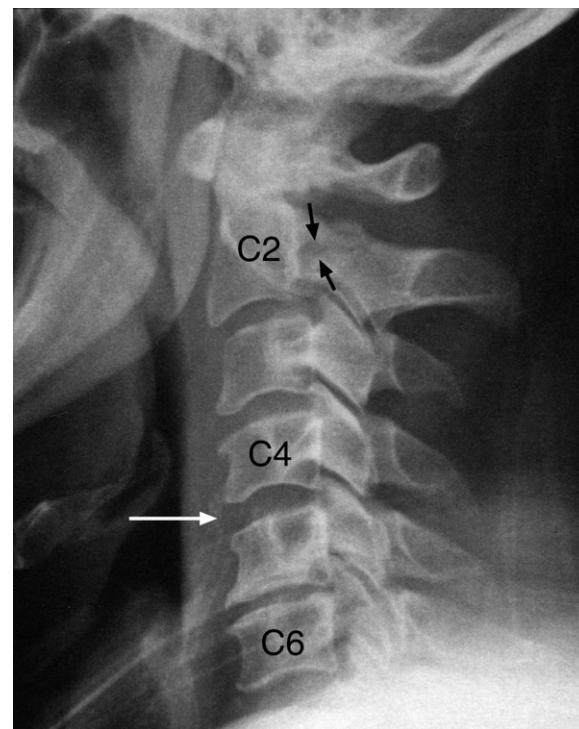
Cervical spine lateral plain X-ray image. Note (i) the anterior slip of C2 on C3 in view of the hangman's fracture at C2 (arrows) (due to associated ligamentous and disc injuries at this level), (ii) the possible compression of the antero-superior aspect of the C4 body, (iii) the widening of the C4–5 intervertebral disc space height anteriorly (white arrow) suggesting that injuries occurred to this intervertebral disc and other soft tissue structures at this level, probably due to an extension type injury to his cervical spine, and (iv) the disc narrowing and osteophytic lipping at the C5–6 level.
